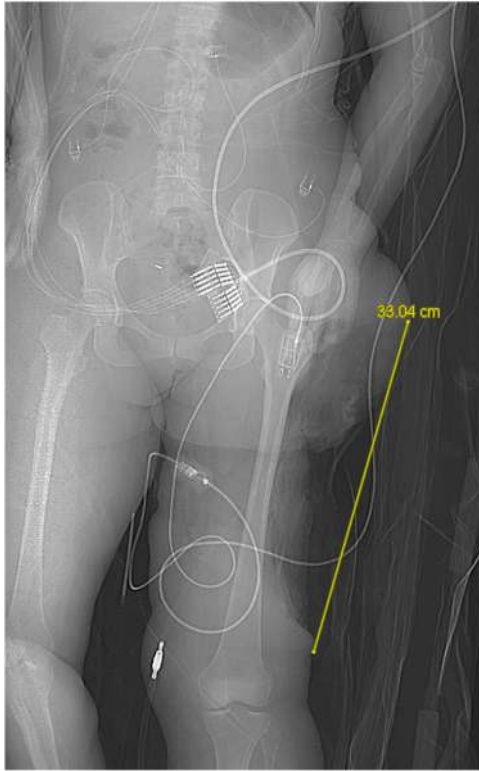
CT scout view of the CT arteriogram of the wound. Photo credit: Joseph Fournier.
